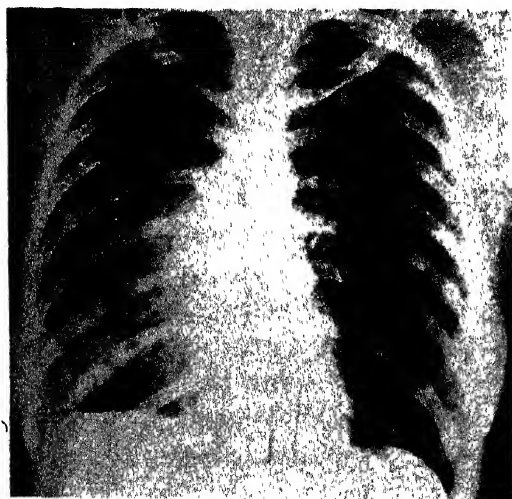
"Cotton-wool" appearance in so-called inverse phase or resolution with new area or unit developing from right upper hilum. (A. E. Seeds and M. L. Mazer : Am. J. Roentgenol.)
